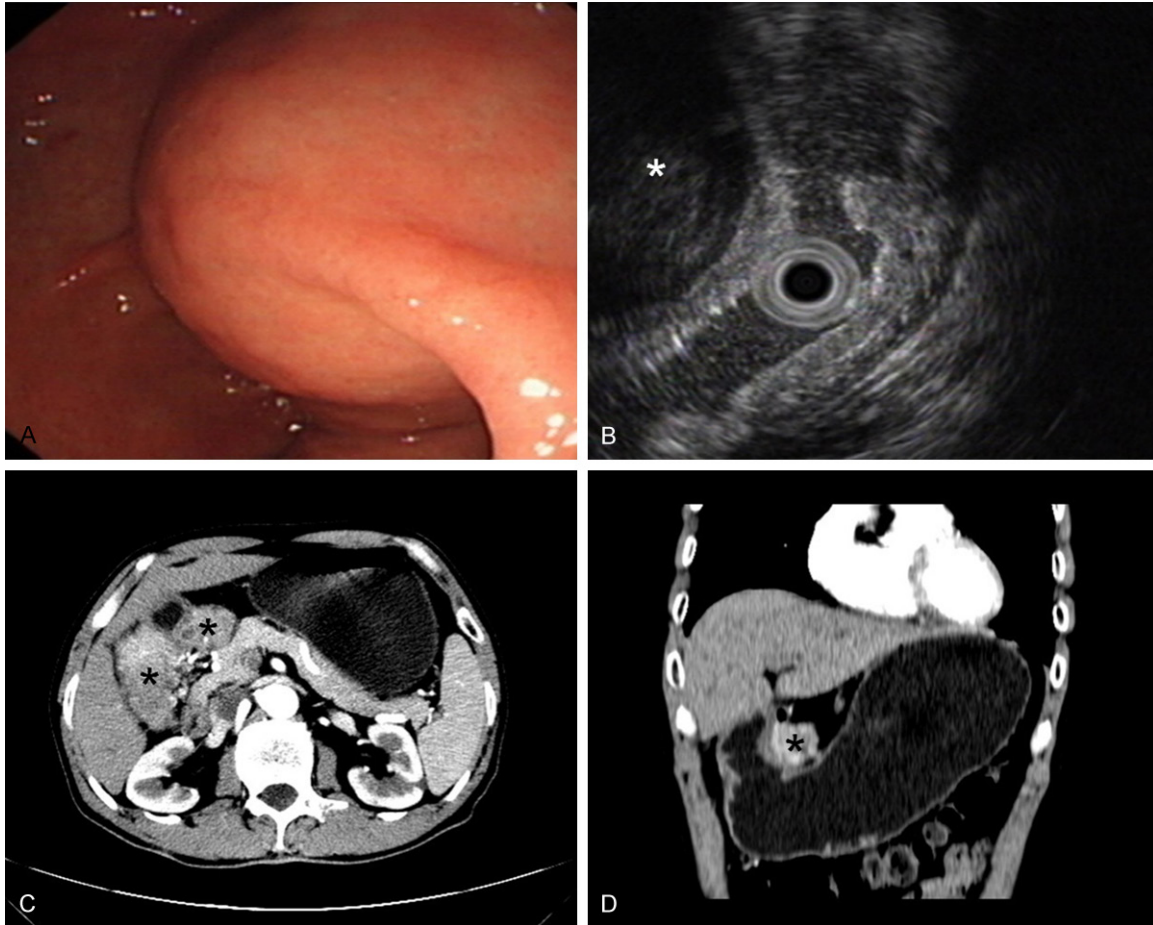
Case 1. A. Endoscopic examination found that the covering membrane of the lesion was protruding without ulcer. B. The result of EUS indicated a submucosa lesion (*). C, D. Spiral CT revealed an irregular mass locating under the mucus membrane of gastric antrum (*). There was no close relationship between the mass and the mother liver.
